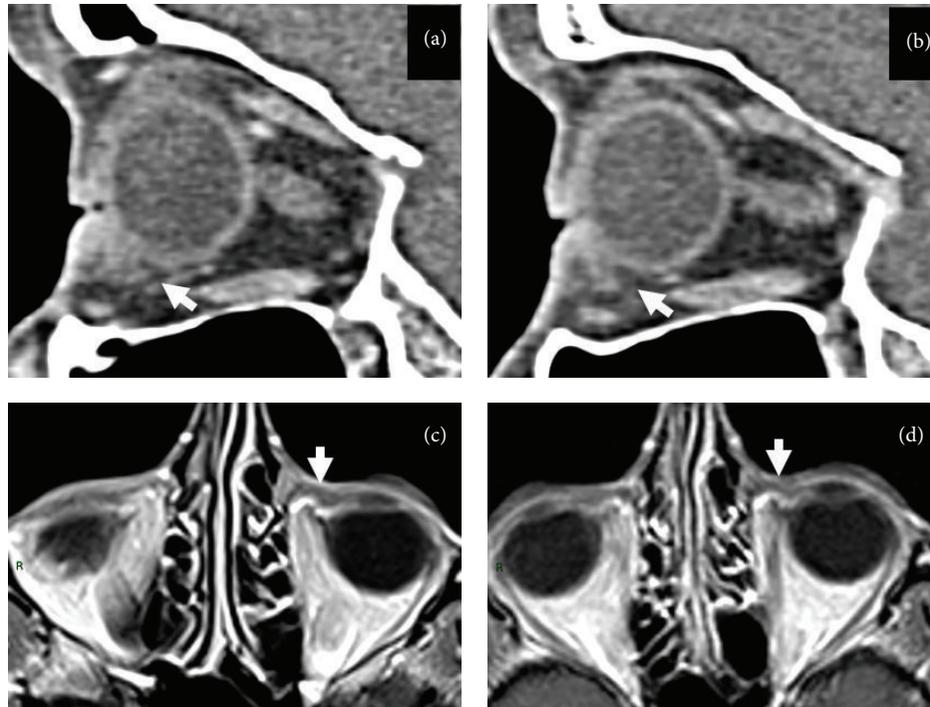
Imaging signs of B cell lymphoma response to therapy. ((a) and (b)) Computed tomography sagittal reformats show focal thickening of the anteroinferior peribulbar conjunctiva on the left side (white arrow in (a)). Compared to the same site in the right orbit (arrow in (b)) where peribulbar hypodense fat tissue is present. ((c) and (d)) Magnetic resonance axial postgadolinium T1-weighted images before (c) and after (d) treatment. Note the size reduction of the focal peribulbar tissue on the left medial conjunctiva (white arrows in (c) and (d)).
